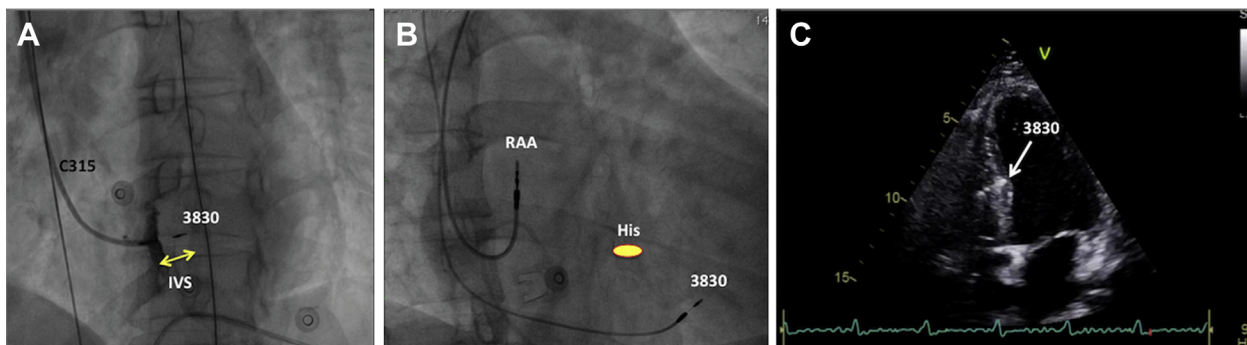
Lead position determined by fluoroscopy and echocardiography. A: The angiography performed using the C315 sheath in the anteroposterior view. B: Fluoroscopic image in the right anterior oblique view. C: Four-chamber view in echocardiography. The *yellow double arrow* shows interventricular septum. The *white arrow* shows the 3830 ventricular lead. IVS = interventricular septum; RAA = right atrial appendage.
